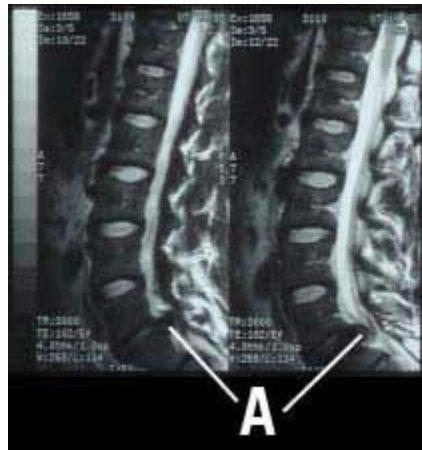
MRI of Lumbar Disc Herniation (sagittal view) (Spine-health.com)
